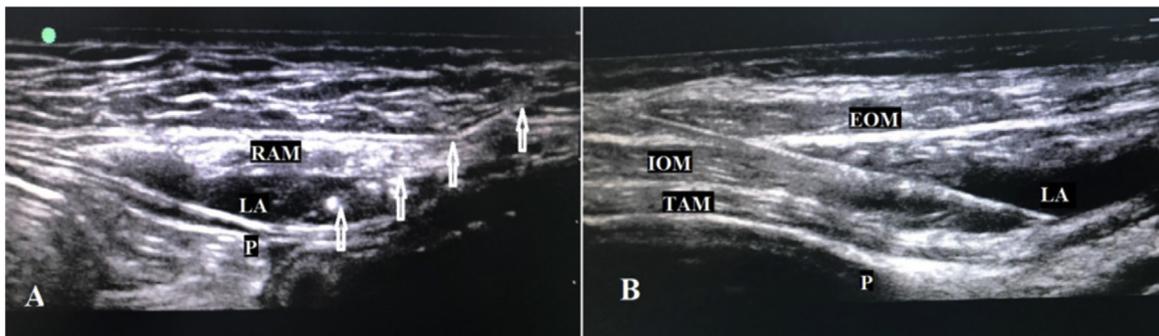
Ultrasonographic appearance of distribution of LA medication between RAM and posterior sheath with needle position for rectus sheath block. (A) Ultrasonographic appearance of distribution of LA medication between TAM and IOM with needle position for transversus abdominis plane block. (B) Arrows point to the needle. RAM, Rectus Abdominis Muscle; LA, Local Anesthetic; P, Peritoneum; IOM, Internal Oblique Muscle; EOM, External Oblique Muscle; TAM, Transversus Abdominis Muscle.
